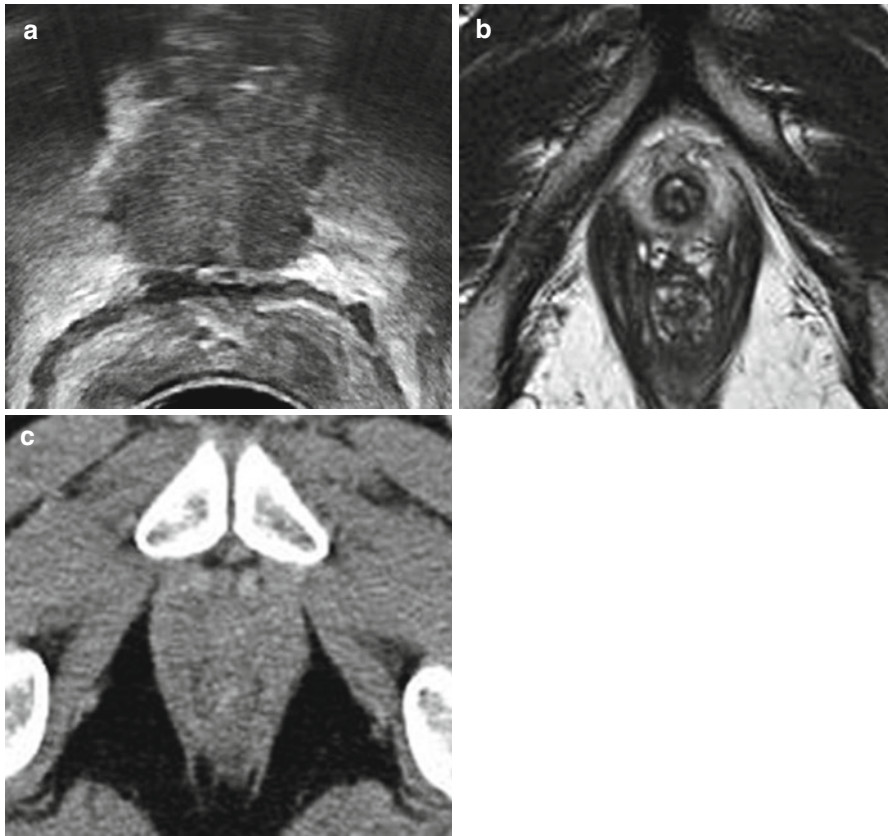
Prostate apex as seen on TRUS (a) MRI (b) and CT (c) in the same patient
